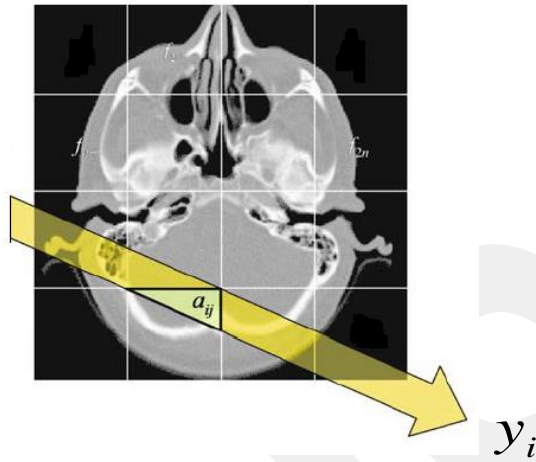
The intersection of X-ray beam and pixels of object. The section of pixel that intersects with X-ray beam included in system equations as weighting term and calculated using Siddon's algorithm [18].
